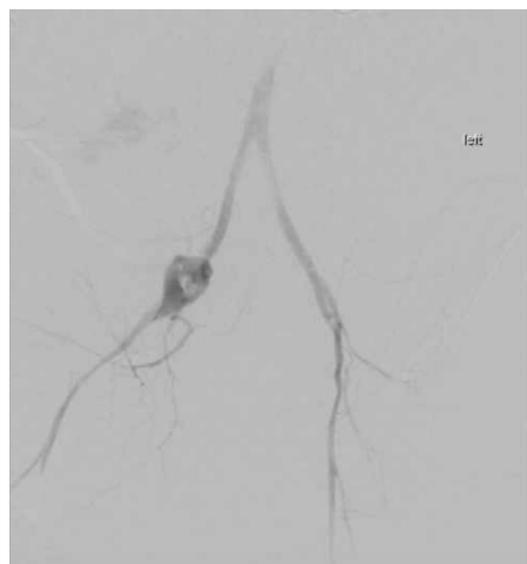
CT Aortography shows aneurysm of right common iliac artery.
